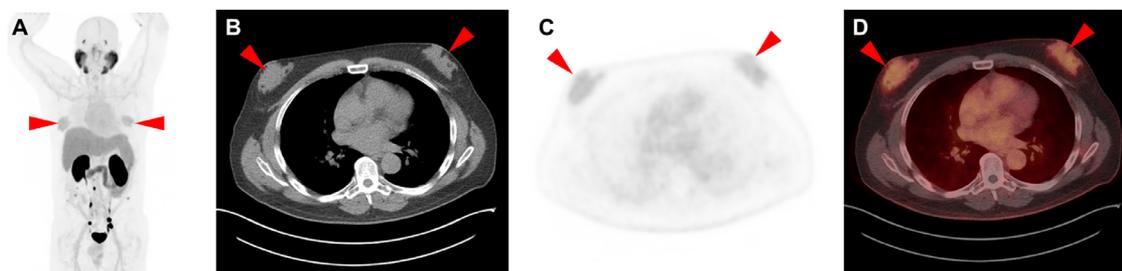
(A) Maximum intensity projection PET image, and (B) axial attenuation-correction CT, (C) axial ^{18}F -DCFPyL PET, and (D) axial ^{18}F -DCFPyL PET/CT images through the chest from a 65-year-old man with recurrent prostate cancer manifest as multiple abdominal and pelvic lymph nodes and peritoneal implants as visualized on the MIP in (A). Note the moderate uptake in gynecomastia (red arrowheads).
